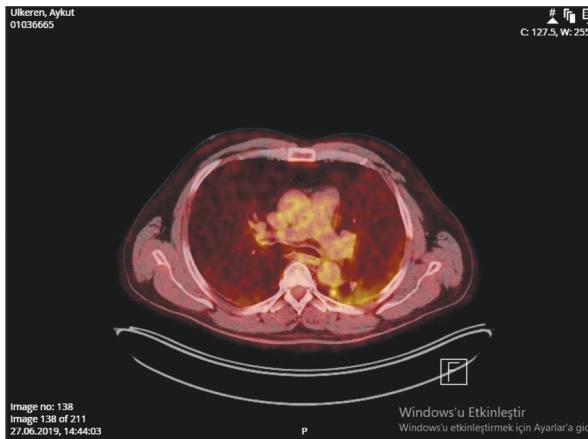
Positron emission tomography with computed tomography image after 3 months of treatment.
